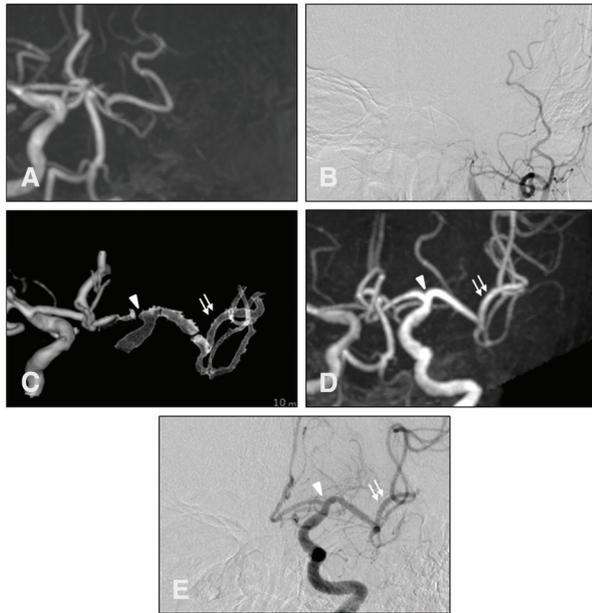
Detection of blood vessels beyond the occluded sites in the left internal carotid artery occlusion case. This figure depicts images obtained in Case 1, with the occlusion point defined as the left ICA. Original 3D TOF-MRA images obtained at admission do not delineate the course of the MCA distal to the ICA (A). Angiography performed prior to MT (B) demonstrates a similar appearance as compared with 3D TOF-MRA at admission (A). Fusion images obtained from 3D T2-weighted SPACE and 3D TOF-MRA reveal the course of the MCA distal to the occlusion (C). The ICA in the petrous bone was difficult to delineate, but the intracranial MCA was well delineated, M1 showed a large run caudally, and the ensuing M2 was open vertically. Therefore, the image delineation was rated “excellent.” MRA images (D) and angiography (E) acquired after MT match the fusion MR images (C) in terms of visualizing the MCA distal to the occlusion. Double arrows and arrowheads indicate the same point in the vessels. ICA: internal carotid artery; MCA: middle cerebral artery; MT: mechanical thrombectomy; SPACE: sampling perfection with application-optimized contrasts using different flip angle evolutions; TOF: time-of-flight
